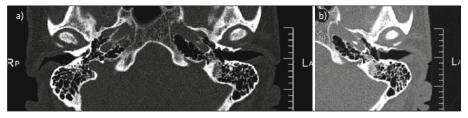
Preoperative CT scans in patient B, axial view, showing: A) bone erosion of the left external auditory canal; B) a soft tissue mass in the left external auditory canal.
